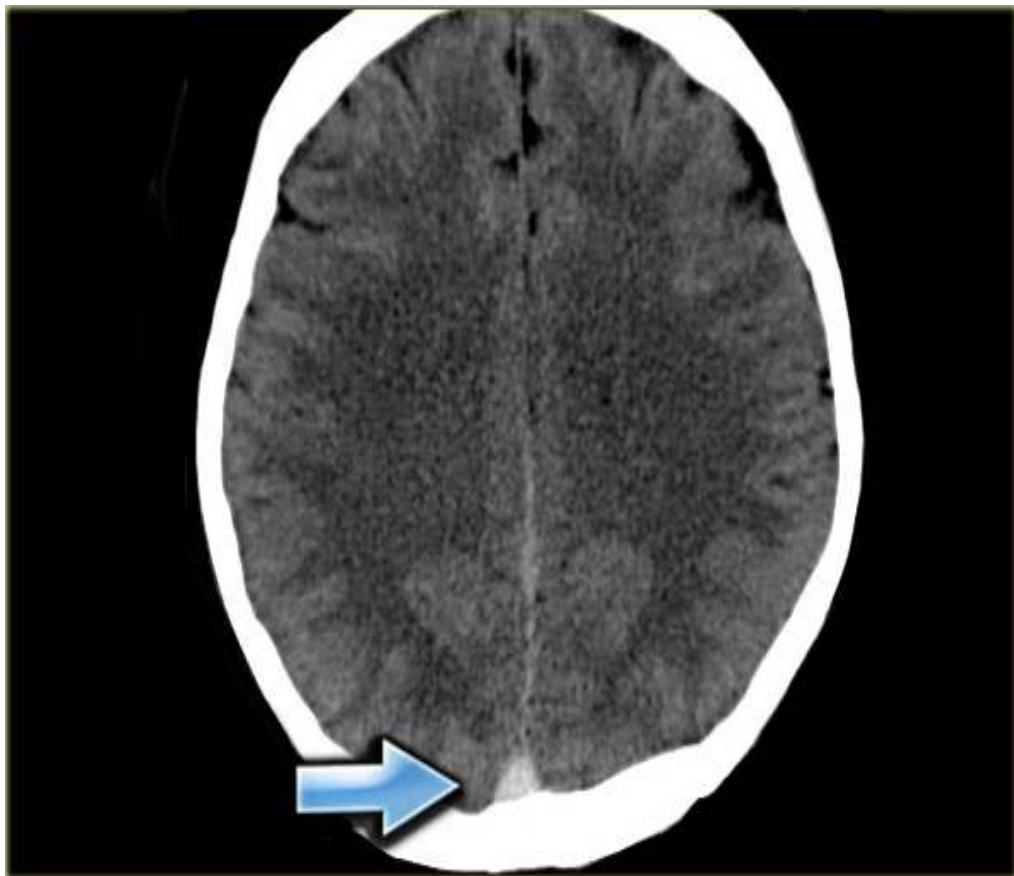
CT Brain showing dense triangle sign
